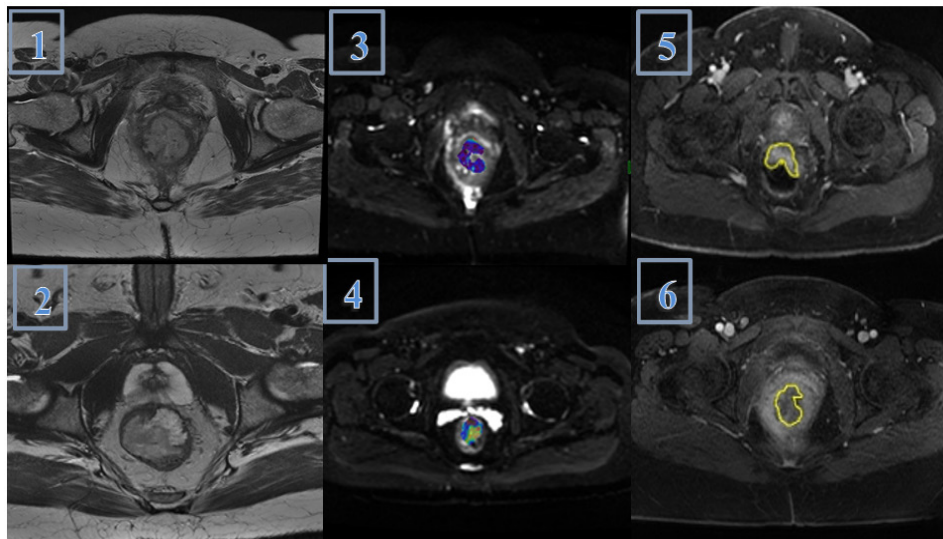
Non-Response Case based on the TRG Criteria. A 63-year-old male with locally advanced colorectal cancer. (1) Axial T2-weighted images of a T3 tumor with extramural fat infiltration. Pre-CRT phase. 2. After -CRT phase.
